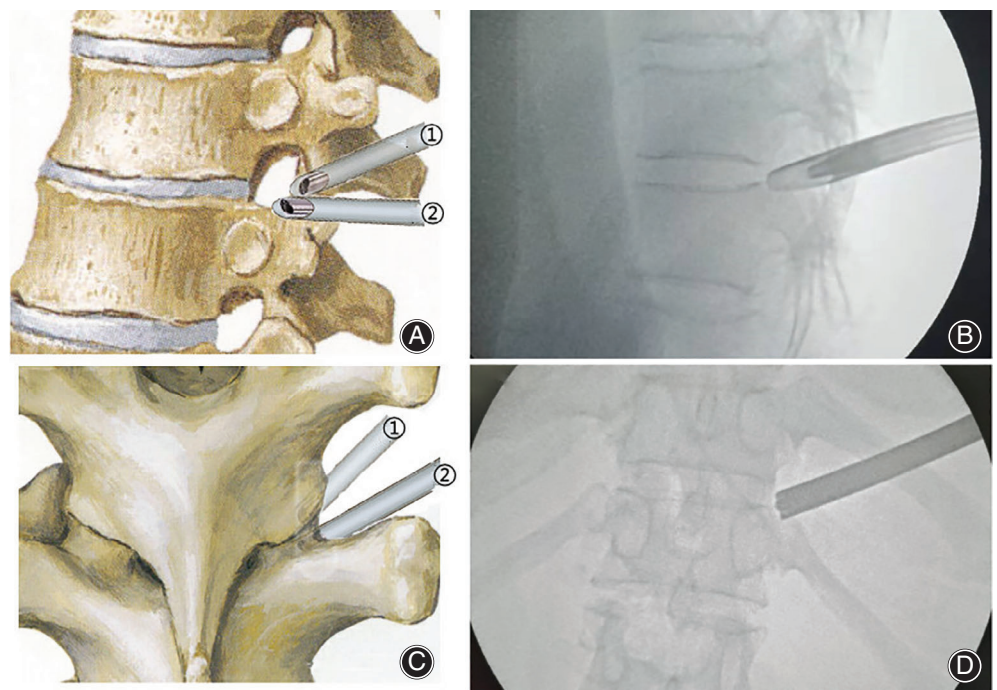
Localization of superior articular process, pedicel, and lower pedicel-ligamentum flavum tunnel (PEFT) under vision. (A) and (C) Lateral and dorsal view of working sleeve and scope location, respectively. ① Working sleeve positioned on the superior articular process, ② The working sleeve is slid caudally to attach the pedicel, rotating the scope to detect the lower border of superior articular process, pedicel, and lower PEFT under vision, respectively. (B) and (D) Sagittal and coronal view, respectively, of working sleeve location under X-ray fluoroscopy.
